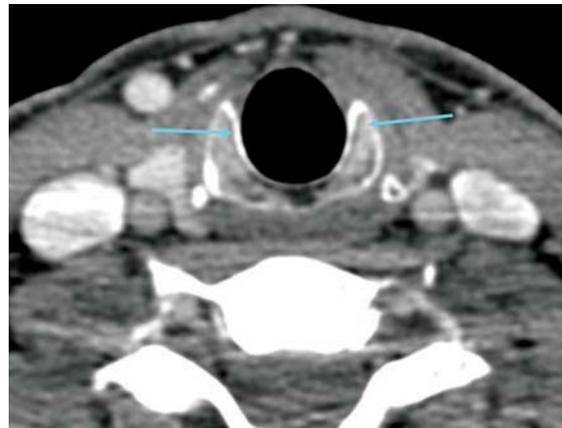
Axial CT section at the subglottic level. Luminal air abuts the inner surface of cricoid cartilage (arrows) as no submucosal tissue is present at this level
